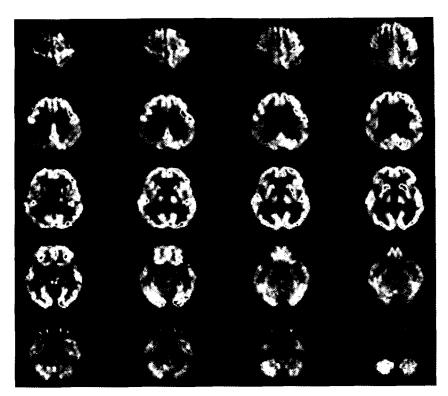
Seventy-five years old male with corticobasal ganglionic degeneration. Axial image of F-18 FDG PET shows asymmetric hypometabolism of frontoparietal cortex, putamen, thalamus and cerebellum.
